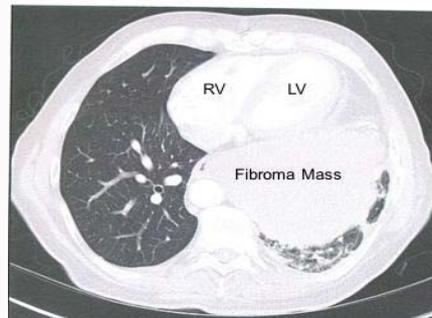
CT scan of chest in 2012 showing a 12 cm size left sided mass, recurrent pleural fibroma, Right Ventricle (RV), Left Ventricle (LV).
